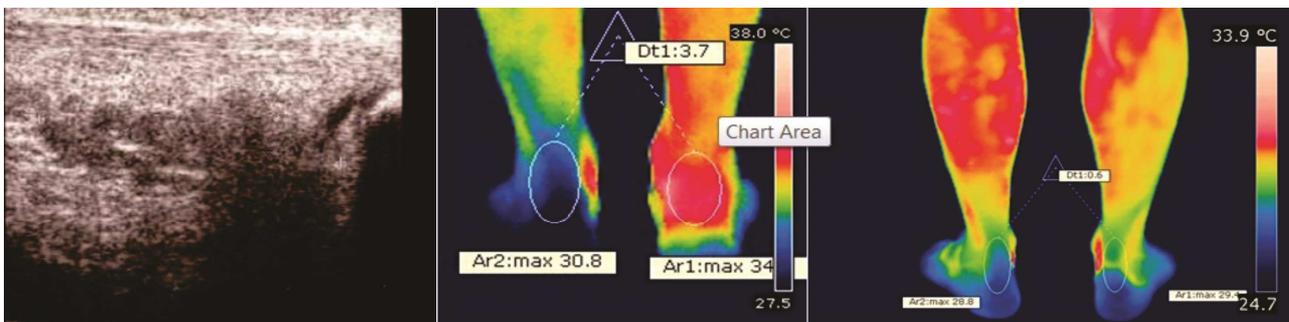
Preachilian bursitis ultrasound and thermography before and after treatment ( $\Delta T$  decrease from 3.7 to  $0.6^{\circ}\text{C}$ )
